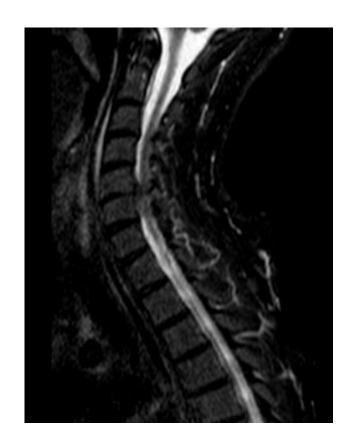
C5/C6 discitis on MRI STIR sequence
